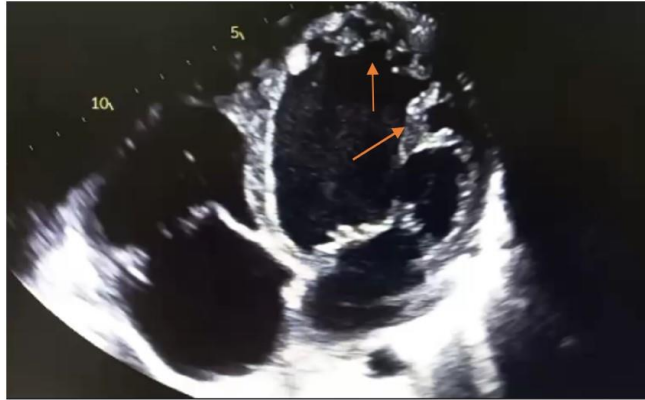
Echocardiography: Apical 4-chamber view showing LV trabeculations.
